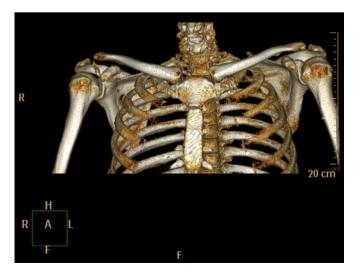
Reformatted computed tomography scan confirming a type I coracoid process fracture, a type IB acromion fracture, and a type II acromioclavicular joint injury.
